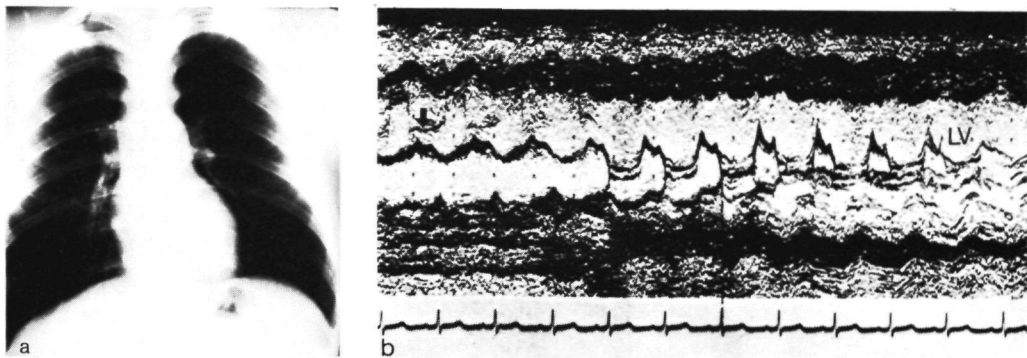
a. Chest X-ray, March, 1977. The heart is not enlarged, normal pattern of pulmonary vascularity.
